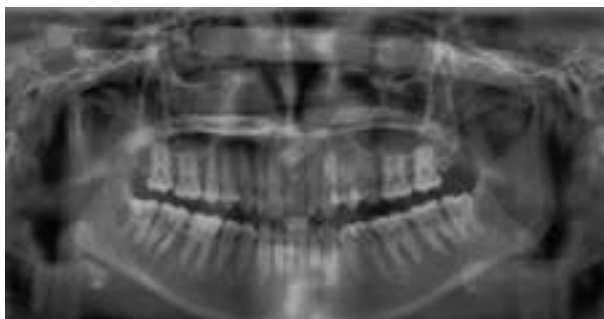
Intra oral panoramic radiograph showed horizontally impacted of left central incisor tooth.
